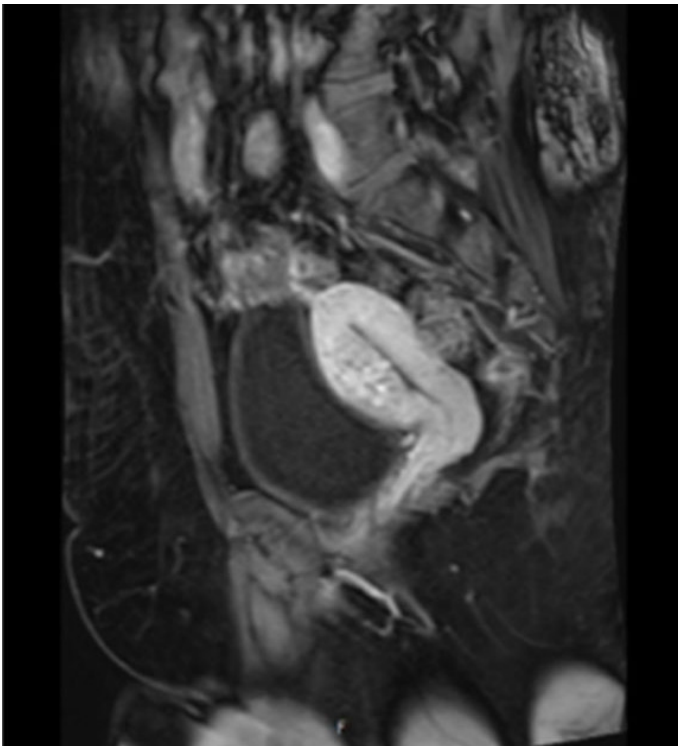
Pelvic MRI of uterine AVM showing abnormal vessels in anterior myometrium.
